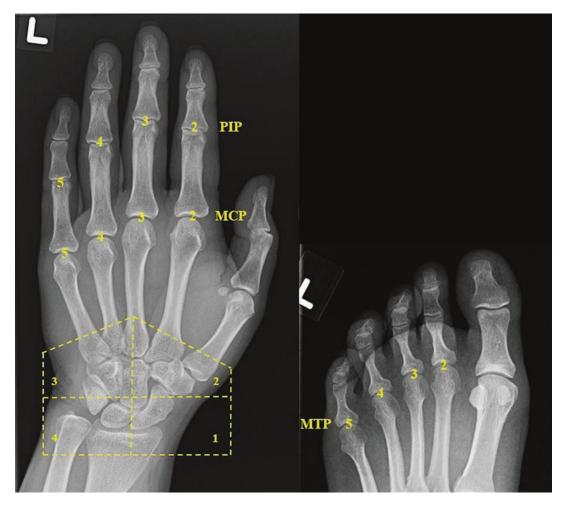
Larsen's scoring method. There are 32 areas for radiographic evaluation in a single patient – eight areas in each hand (2nd–5th MCPs and PIPs), four areas in each wrist (quadrants), and four areas in each foot (2nd–5th MTPs)
